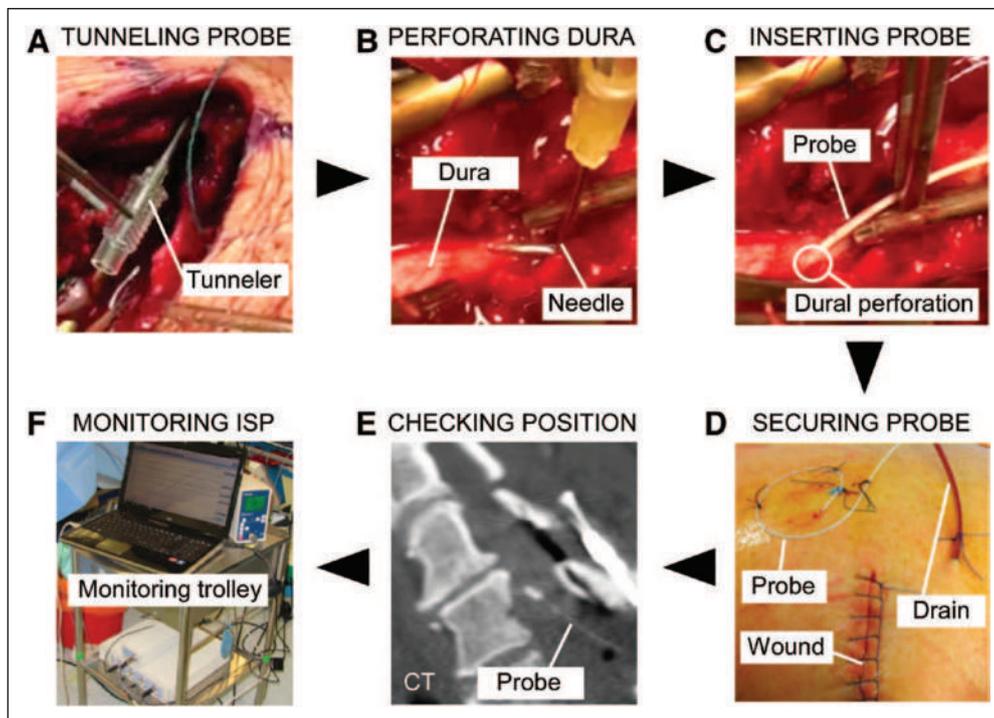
Intraspinal pressure (ISP) monitoring technique. A, A tunneler pulls the Codman pressure probe through the skin into the wound. B, The dura is perforated with a 90° bent needle one spinal level below the injury. C, The Codman probe is inserted through the dural perforation. D, The surgical incision is closed and the probe secured to skin using silk sutures. E, CT checks probe position. F, Data monitoring trolley kept behind the patient bed in ICU. Trolley carries the laptop, Codman intracranial pressure box, and Powerlab system.
